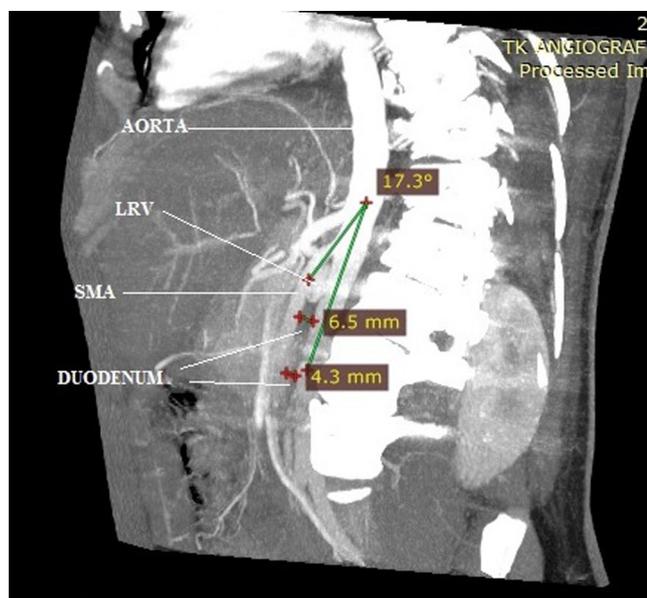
An image of abdominal CT scan with contrast, the angle of the SMA ramification from the aorta is approximately 17°, the level of the duodenum is of 4.3 mm to 6.5 mm between the SMA and the aorta. SMA – superior mesenteric artery; LRV – left renal vein.
